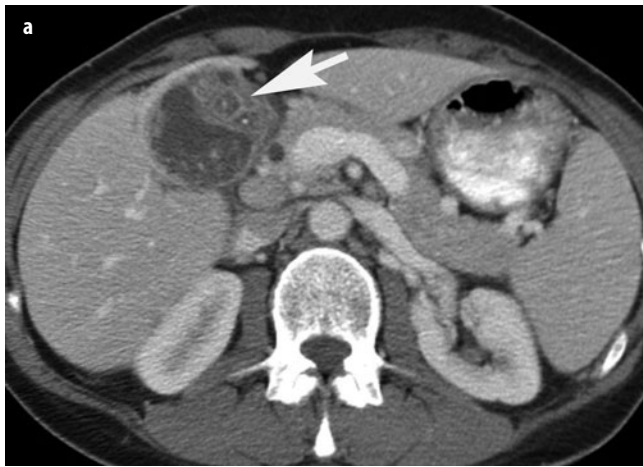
a, b. Xanthogranulomatous cholecystitis. Contrast-enhanced computed tomography (CT) using intravenously and orally administered contrast media shows asymmetric thickening of the gallbladder wall. Round foci of hypoattenuation (a, *arrow*) are visible within the thickened wall. The process invades the adjacent liver (b, *arrowhead*)
